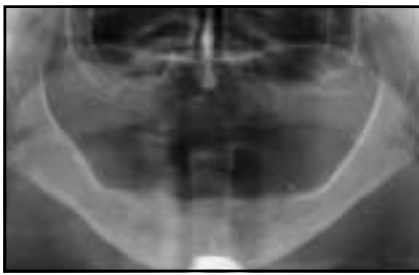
Preoperative panoramic radiograph showing the minimal bone available superior to the inferior alveolar canal in the edentulous molar region.
